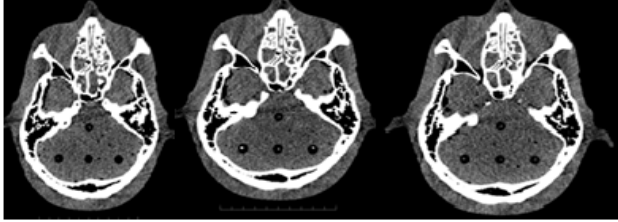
CT slices 100, 101 and 102 for TL dosimetry
